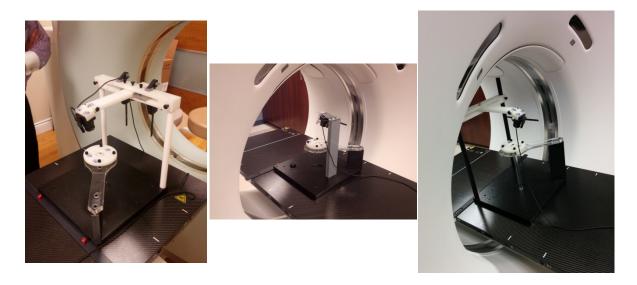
1st version Setup for CT scan (Left), Improved version with a single upright beam (Middle), and the Latest Version with Tight Screws (Right).
